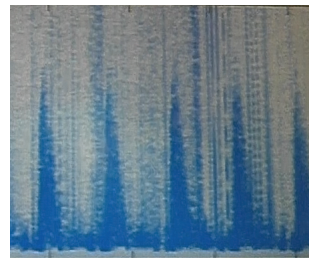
Inpatient variability across measurement sets, captured by USCOM display at IPP and collected from participants by an expert sonographer.
